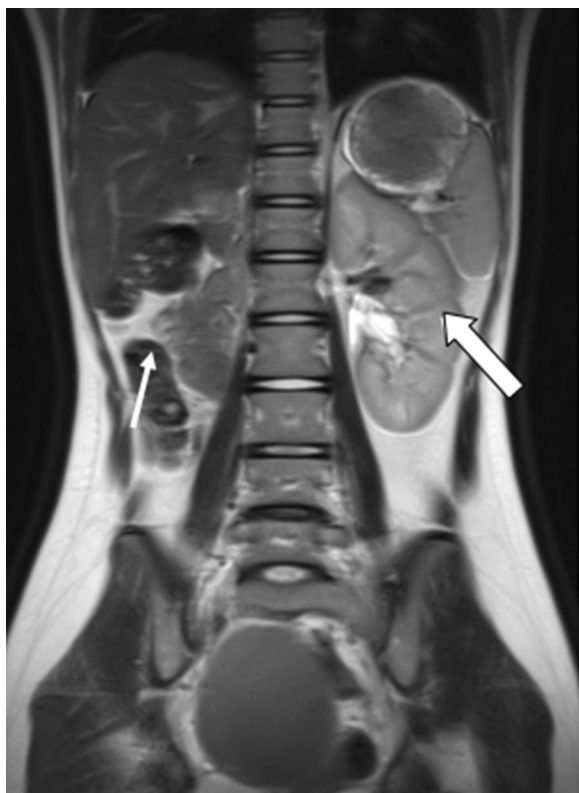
MRI T2-weighted coronal images. Absent right kidney in right renal fossa (thin arrow) with left kidney showing compensatory hypertrophy (thick arrow)
